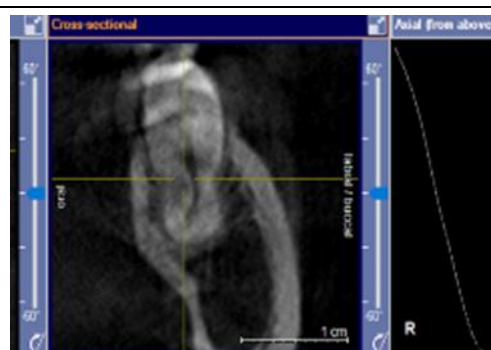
CBCT evaluation – disto oblique view
